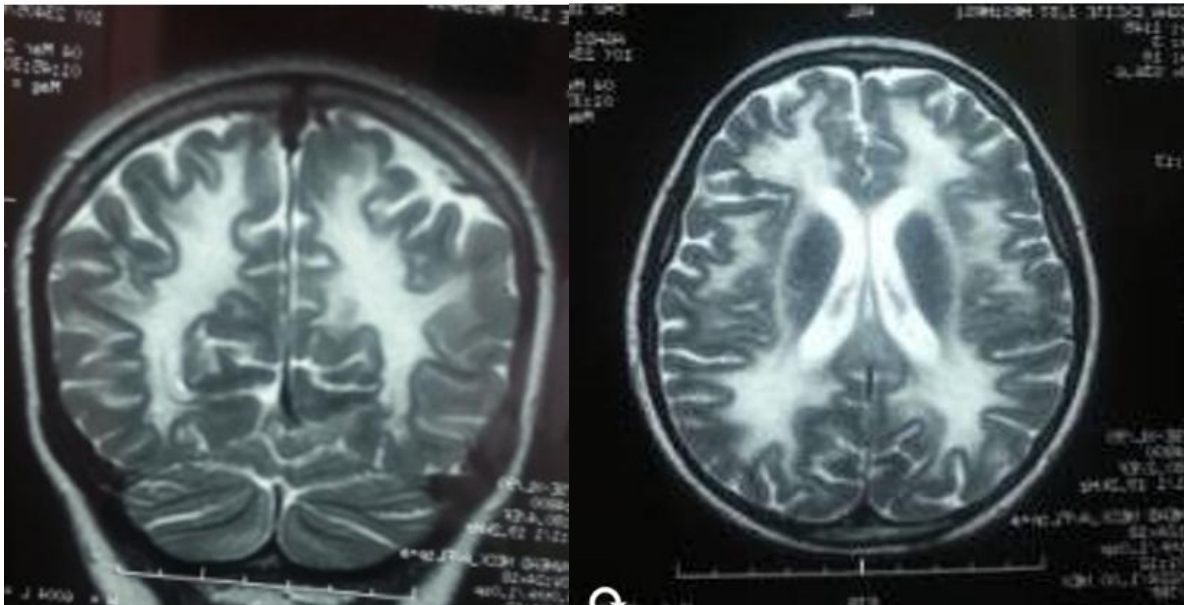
and Figure 2: There is a diffuse, bilateral, and symmetrical T2 and FLAIR hyperintense signal with T1 hypointensity of the white matter, predominantly in the fronto-temporal regions, sparing the U-fibers. Within this hyperintense area, there are T2 hypointense bands, mainly in the frontal horns. This pattern is suggestive of diffuse supratentorial white matter involvement: leukodystrophy.
